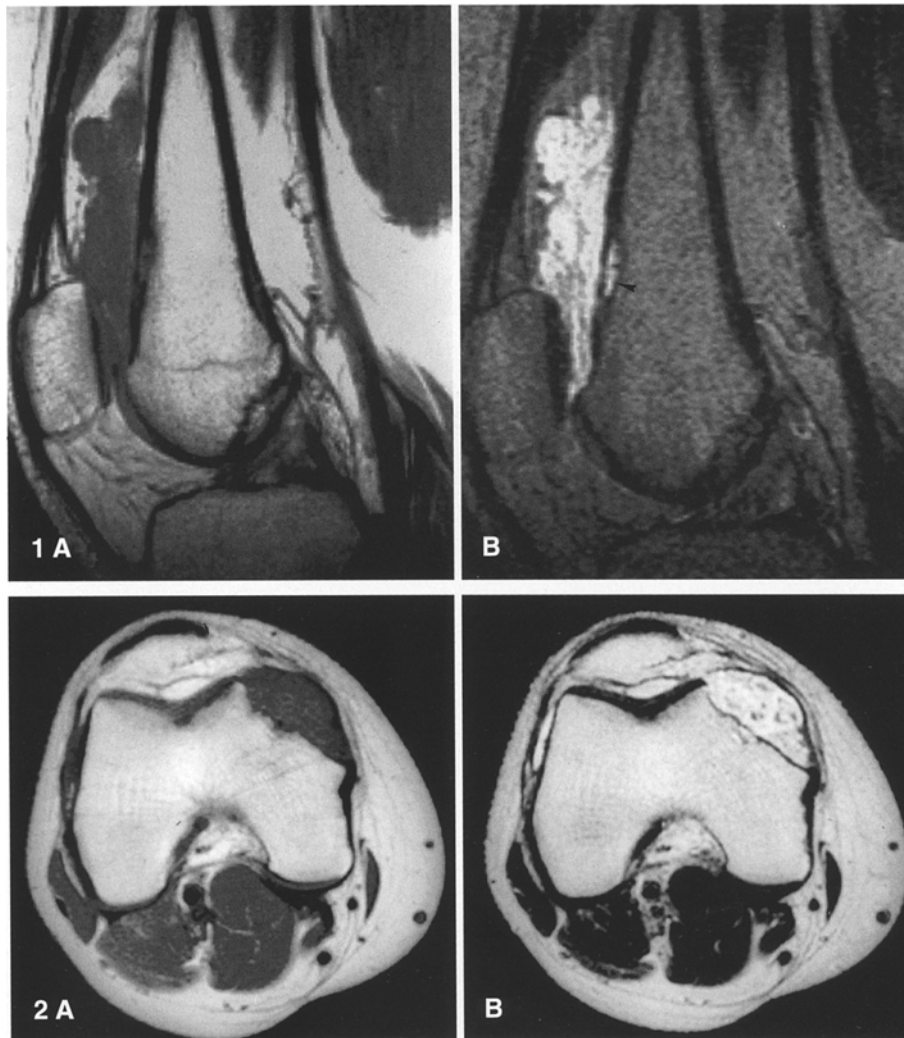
A Sagittal T1-weighted (600/20) image shows a lobulated lesion 5 cm in length in the suprapatellar bursa of the knee. The lesion is well-defined and homogeneous, with a signal intensity similar to that of skeletal muscle. B In the sagittal T2-weighted image (2100/80) the signal intensity of the lesion is higher than that of fat. Small linear and punctate low-signal areas are present within the lesion. This sequence reveals erosion of and abnormal signal intensity in the adjacent femoral cortex (*arrow-head*), which probably represents osseous involvement
